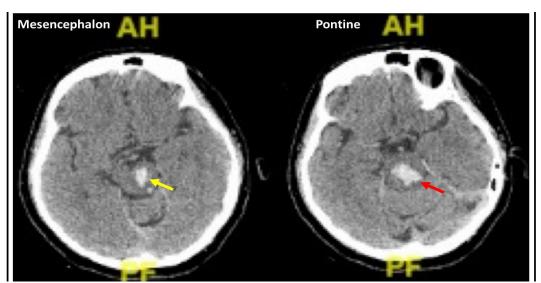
Non-contrast head computed tomography (CT) performed at stroke onset demonstrates a hyperdense lesion extending from the pontine region (right image, red arrow) to the mesencephalon (left image, yellow arrow), consistent with acute intracerebral haemorrhage
